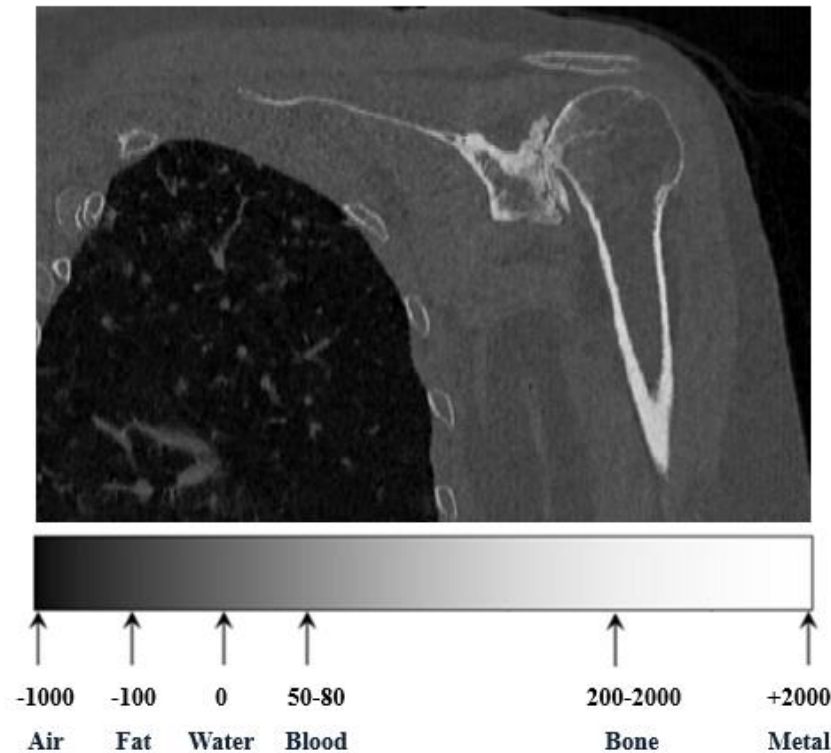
Hounsfield scale showing corresponding CT numbers for different substances.
